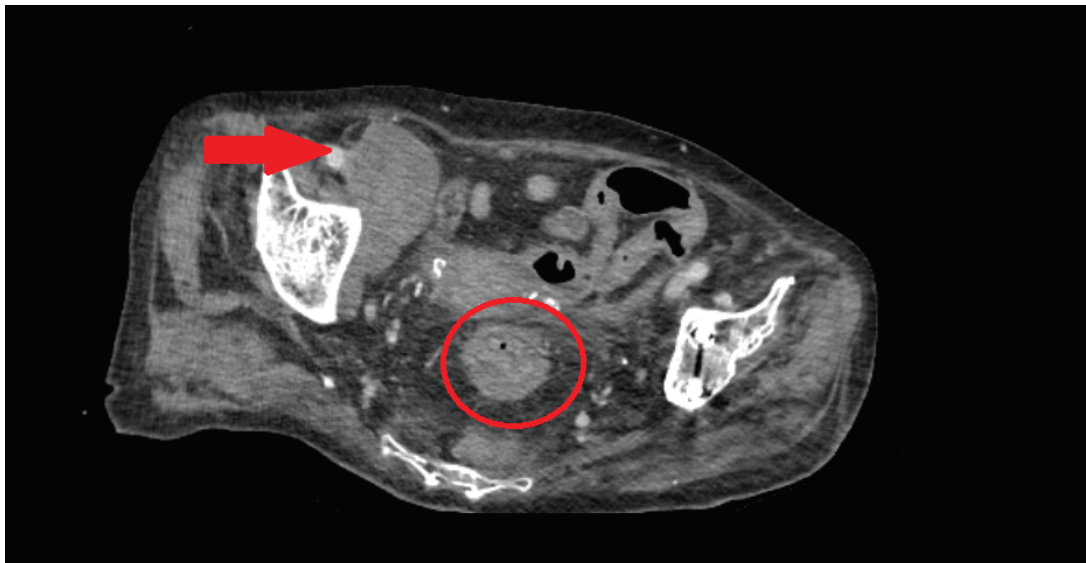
CT image: A mass extending from the right iliac region to the obturator fossa (indicated with an arrow) and thickened rectal wall (circled)
